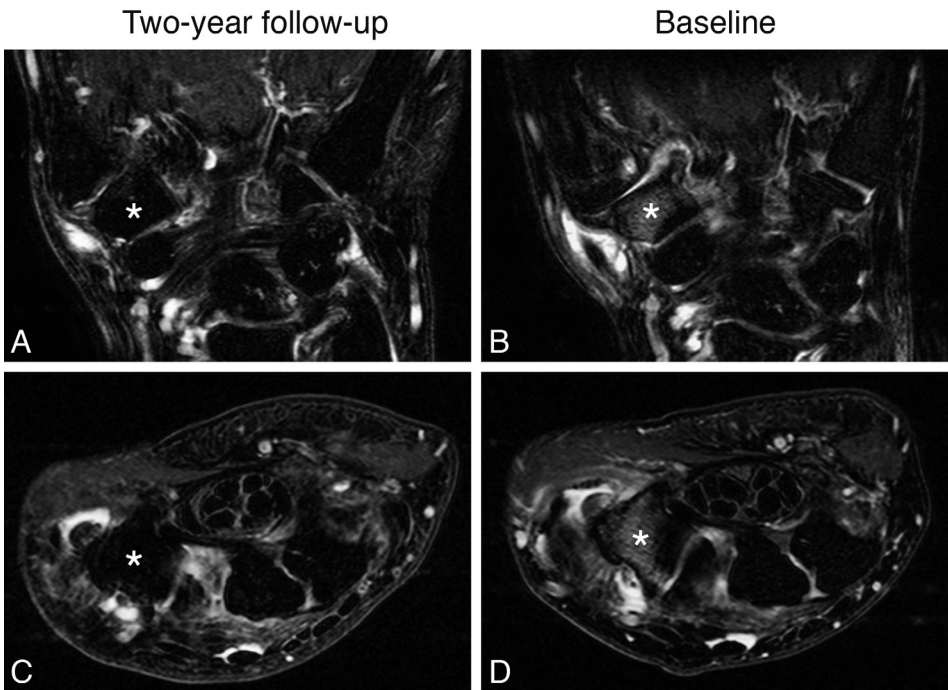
Coronal (A, B) and axial (C, D) fat saturated T2-weighted FSE MR imaging showing decrease in bone marrow lesions in the trapezium bone (asterisks) at the two-year follow-up visit (A, C) compared to baseline (B, D).
